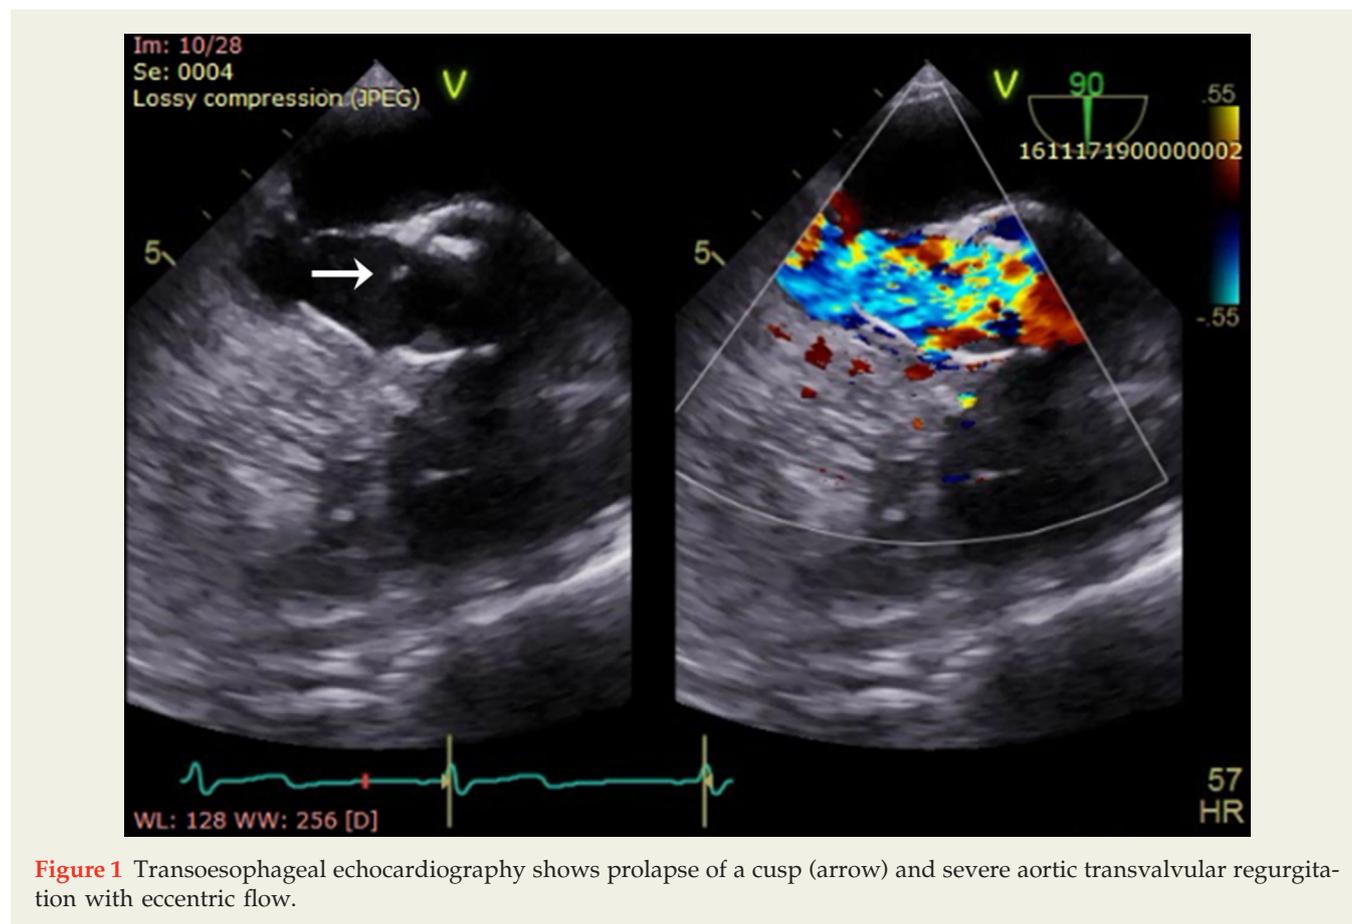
Transoesophageal echocardiography shows prolapse of a cusp (arrow) and severe aortic transvalvular regurgitation with eccentric flow.
